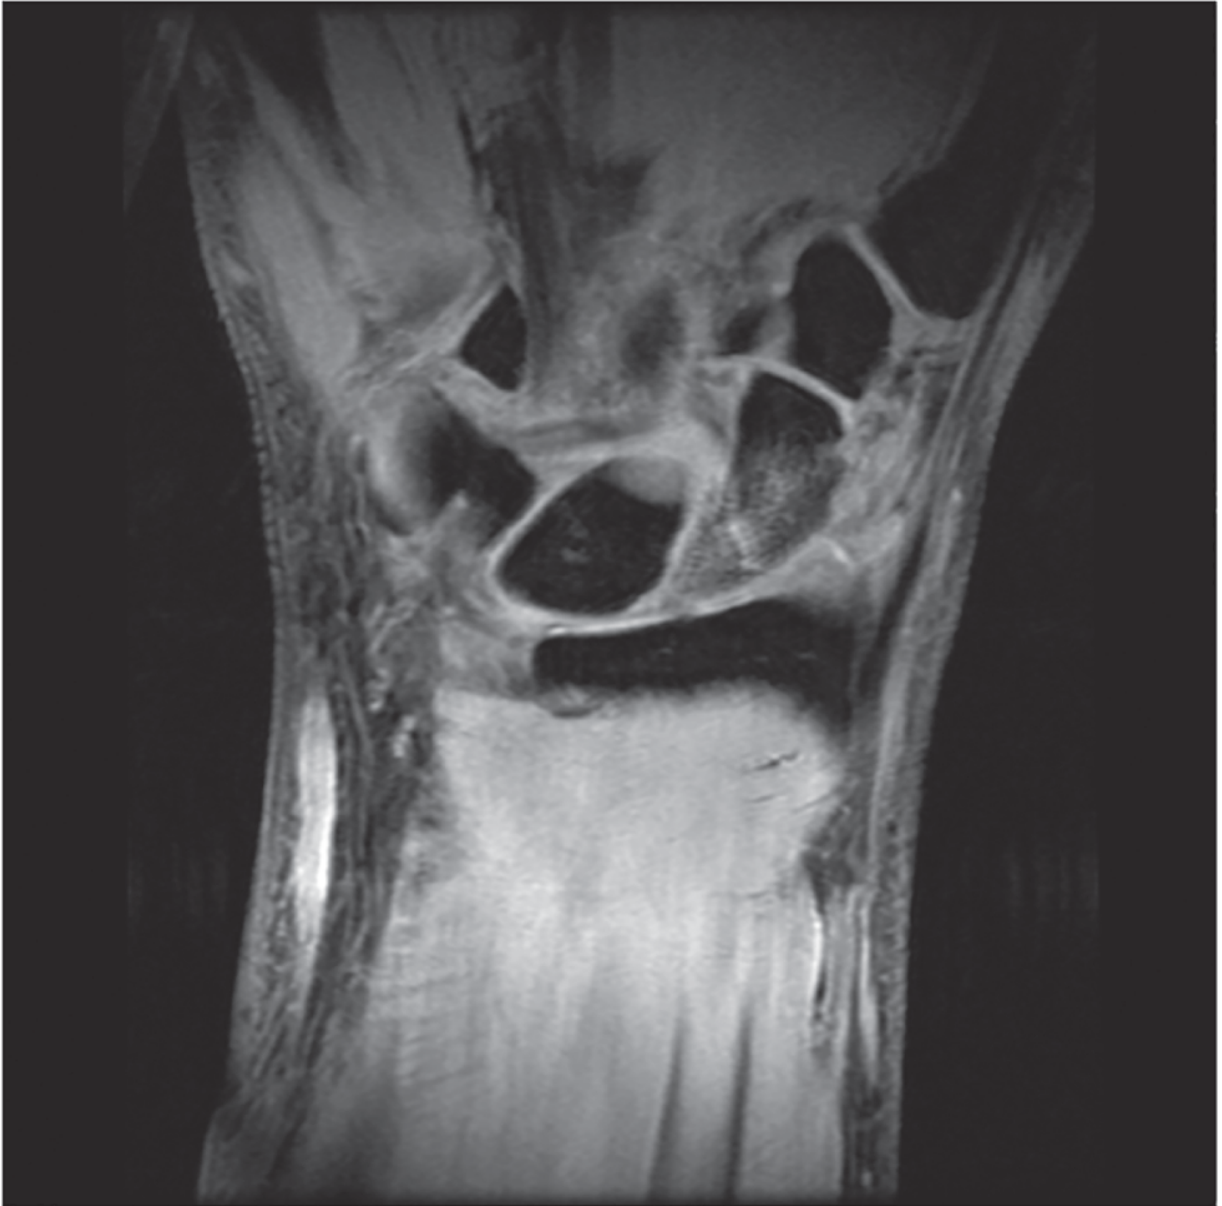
Coronal Fat Sat T2 MRI confirming a suspected proximal pole fracture of the scaphoid.
